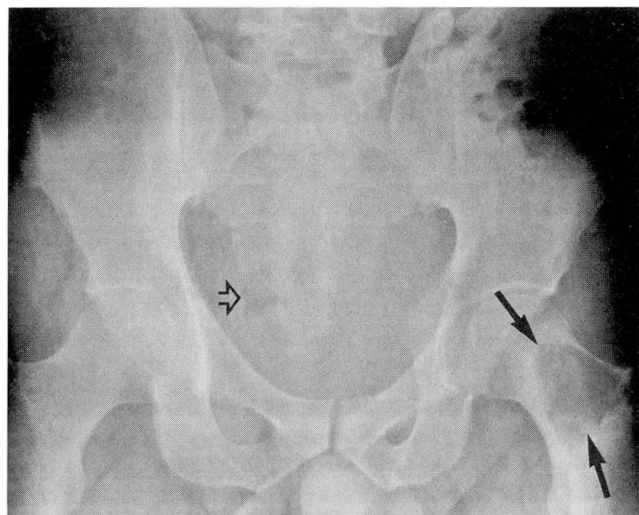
Pelvic radiograph demonstrates a well-defined lytic lesion of the left femoral neck (straight arrows). A small amount of gas is noted in the rectum which lies in the right hemipelvis (open arrow).
